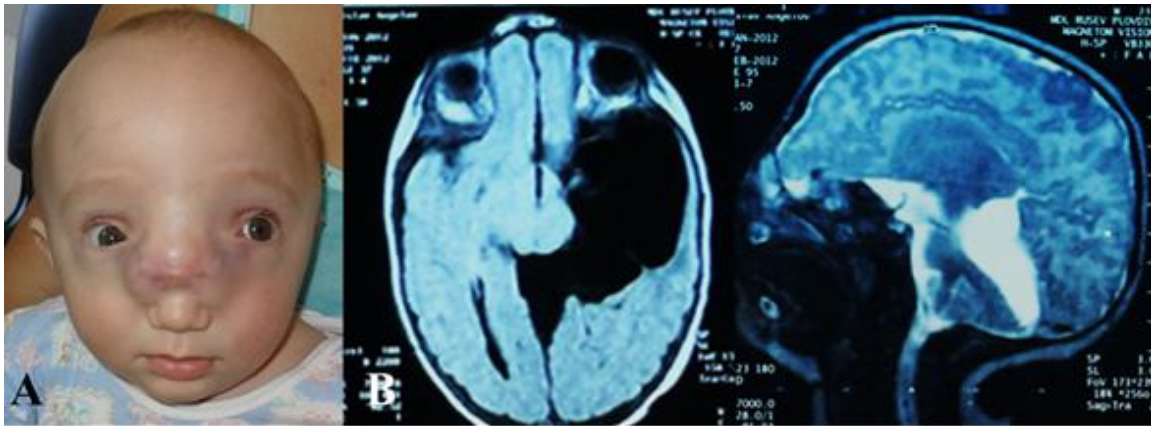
Patient with: A/ frontal encephalocele and hypertelorism; B/ MRI image of the same case demonstrates the sac which contains fluid and altered brain tissue
